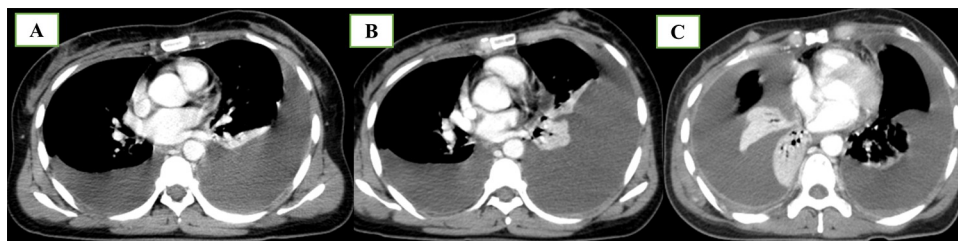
(A) CT scan after neoadjuvant therapy, (B) after three cycles of paclitaxel-carboplatin and (C) at the end of primary treatment.
